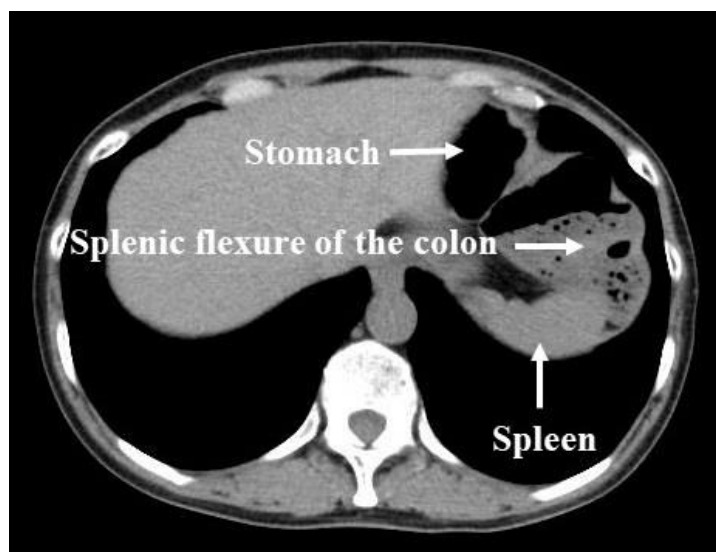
Preoperative CT revealed that the splenic flexure of the colon was located left side of the spleen and closely adjacent to the diaphragm.
